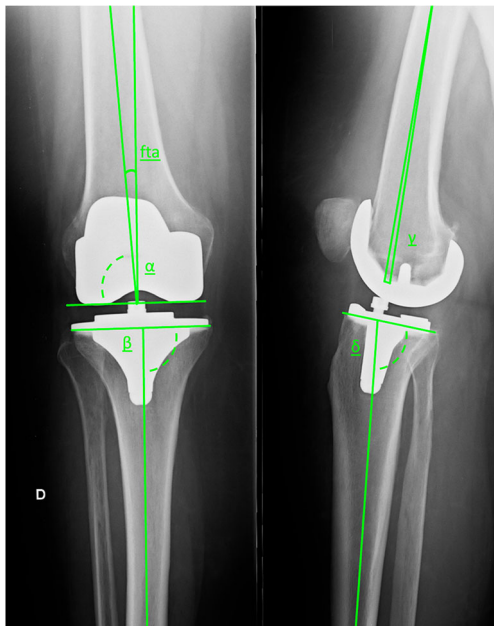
The Knee Society Total Knee Arthroplasty Roentgenographic Evaluation and Scoring System by Ewald [20]. The femorotibial angle (or FTA) is the angle between the femoral and tibial anatomic axes; the alpha angle is the angle of the coronal femoral component alignment; the beta angle is the angle of the coronal tibial alignment; the gamma angle is the angle of the sagittal femoral component alignment; the delta angle is the angle of the sagittal tibial component alignment
